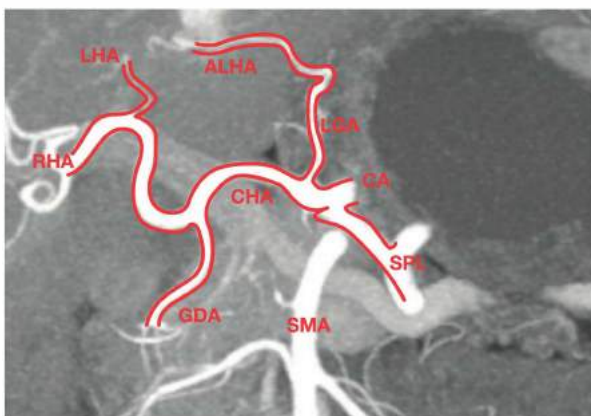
• CT angiogram showing an accessory left hepatic artery (ALHA) coming off of the left gastric artery (LGA). The right hepatic artery (RHA) is seen coming off in normal anatomic position, from the common hepatic artery (CHA) just after it gives off the gastroduodenal artery (GDA). The true left hepatic artery (LHA) is also seen, although it is far less pronounced than the RLHA which is the dominant arterial supply to the left hemiliver. Also shown are the following: SMA, celiac axis (CA), and splenic artery (SPL).
